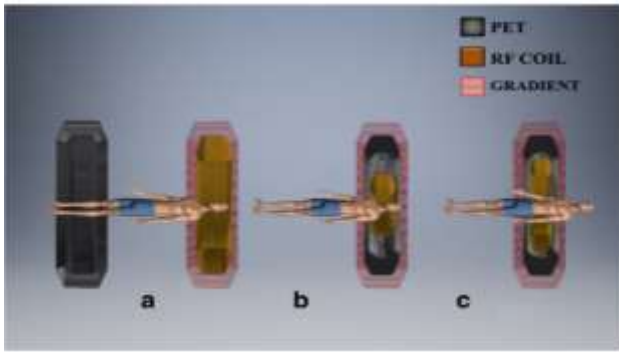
A sequential design, a simultaneous PET insert MRI scanner, and a simultaneous completely integrated system are the three different PET/MRI designs
